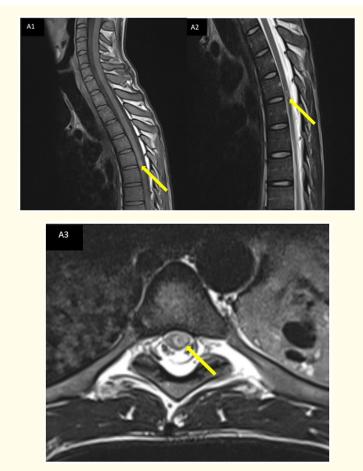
A3: MRI of the thoracic marrow. T1 (A1) sagittal slices, T2 (A2) sagittal slices, and T2 axial (A3): left-sided intramedullary signal anomaly on stage D5-D6, rounded, well limited, in central hypo signal, discrete peripheral hyper signal T1 and T2, surrounded by lesional peri edema in hyper signal T2, measuring 6x6mm (Yellow arrow).
